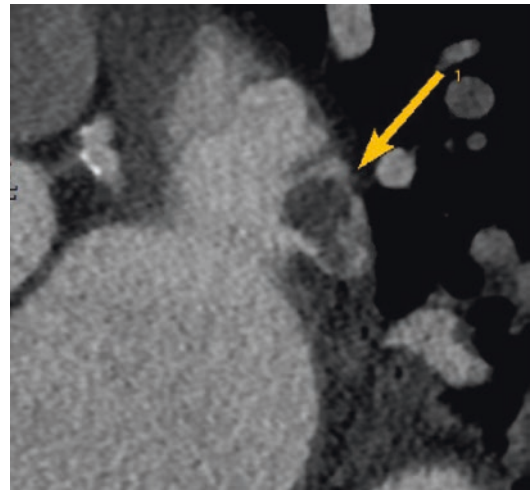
Yellow arrow shows a markedly enlarged left atrial appendage (LAA) with the organized thrombus on CT imaging. DOACs are contraindicated for treatment of thrombus associated with mitral stenosis
